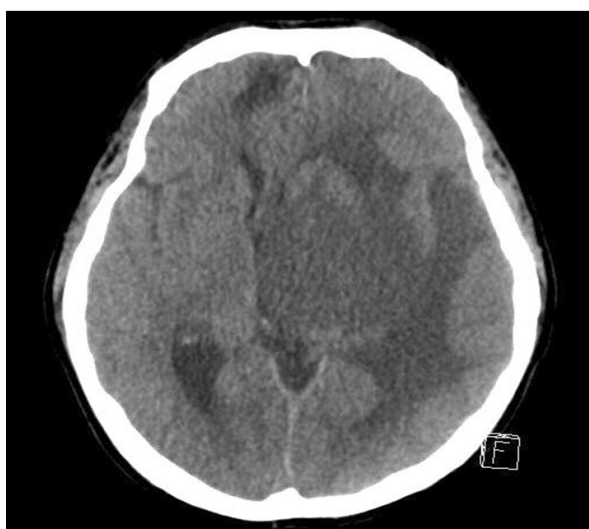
Brain computed tomography shows brain tumor with adjacent edema and mass effect in left cerebral hemisphere.
